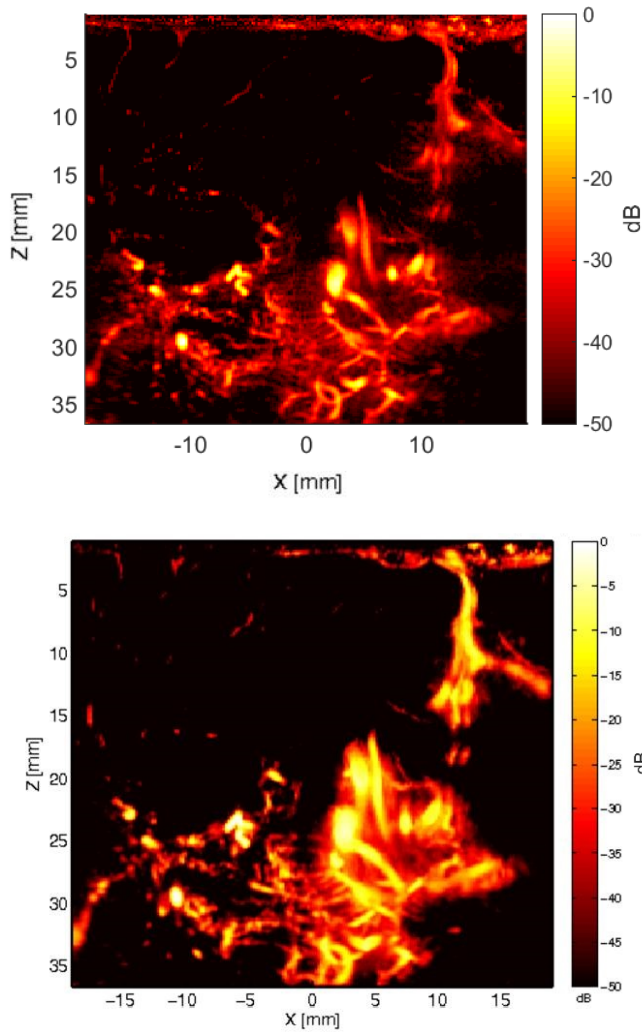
In vivo* Perfusion image of a cerebral glioma:(upper) Power Doppler with SVD method, (lower) Power Doppler with RPCA method
